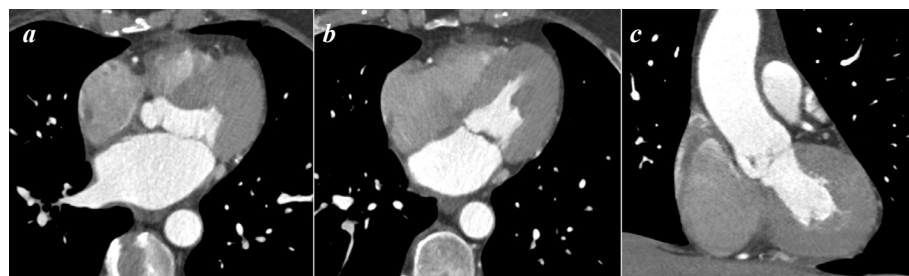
Cardiac CT, monophasic contrast enhancement, arterial phase (a, b - axial reconstructions, c - coronal reconstruction). High contrast between the myocardium and the blood in the left cardiac chambers. Contrasting of the right cardiac chambers insufficient for surface mapping due to the constant flow of non-contrasted blood from the IVC.
